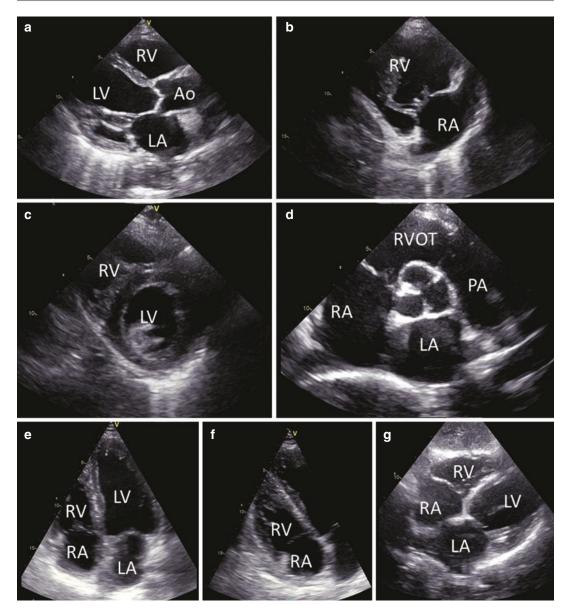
Transthoracic echocardiographic assessment of the right ventricle. Conventional transthoracic echocardiographic acquisitions of the right ventricle (RV) include the parasternal long-axis view (panel a), imaging the RV anterior wall, the parasternal long-axis view of the RV inflow (panel b) to visualize the inferior and anterior walls, the parasternal short-axis view at mid-ventricular level (panel c), showing the inferior lateral and anterior
